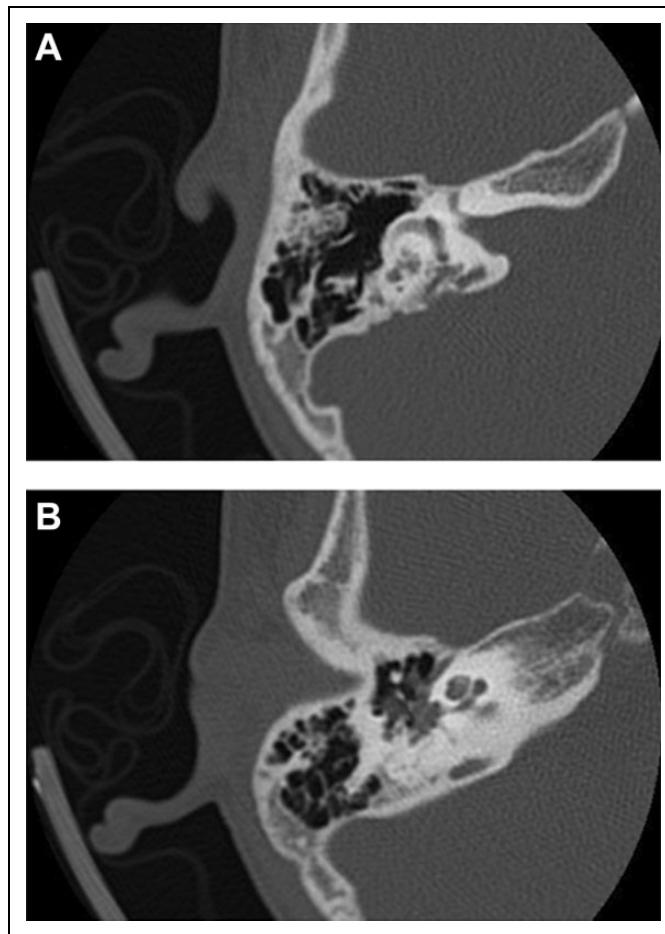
Computed tomography scan of the right temporal bone without contrast shows internal auditory canal widened to 7 mm, indicating an expansile mass with erosion along the posterior petrous bone (A) and the cochlea (B).
